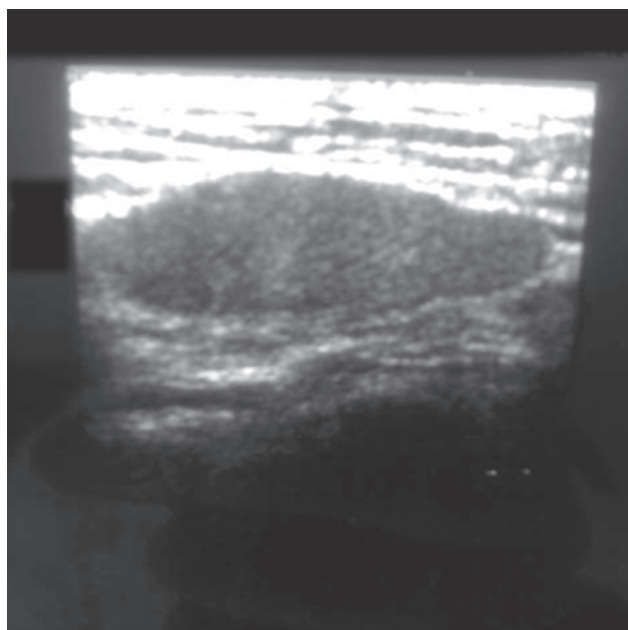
Ultrasound showing testis in right inguinal canal
